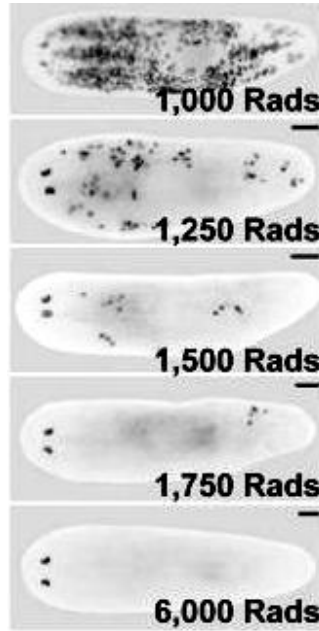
Planaria that exposed to different doses of X-rays (1000–6000 rads). Neoblasts are visualized in the body of each worm, which allows estimating their number
